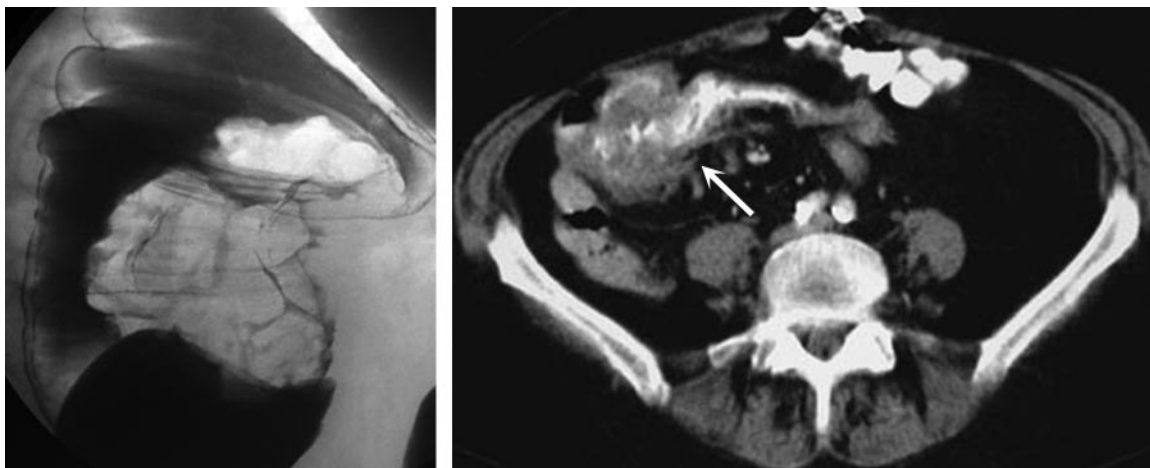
Cecal carcinoid tumor. (a) Image from a double contrast barium study demonstrates a polypoid cecal mass that was biopsied colonoscopically and proved to be a carcinoid tumor. (b) Axial CT image shows circumferential thickening of the cecum (arrow).
